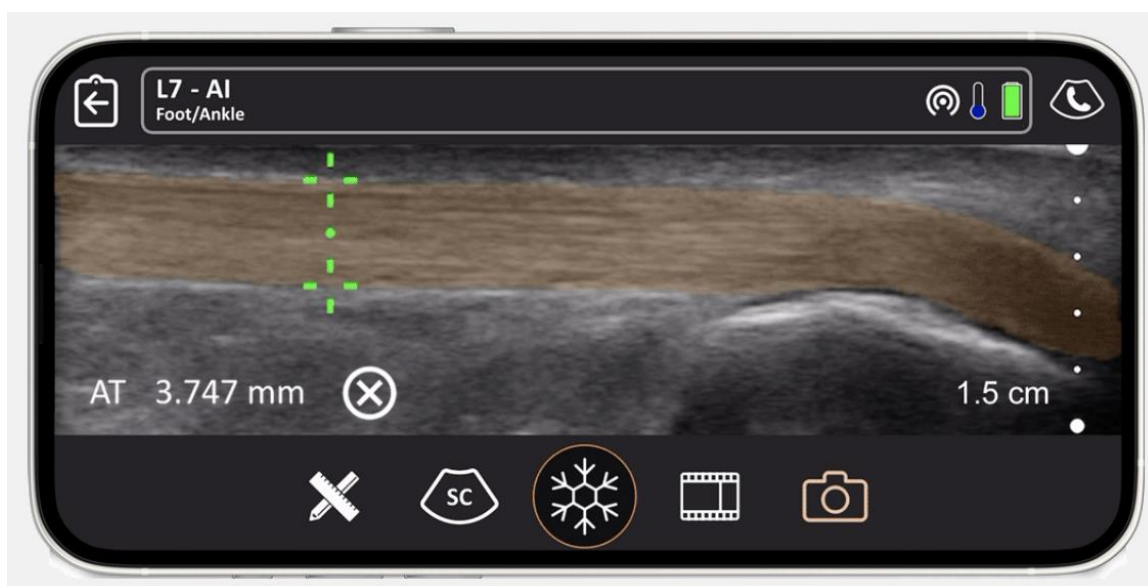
Example of an AI-powered ultrasound scan of the Achilles tendon, with automatic identification and measurement of the Achilles tendon. From [Clarius](#).
